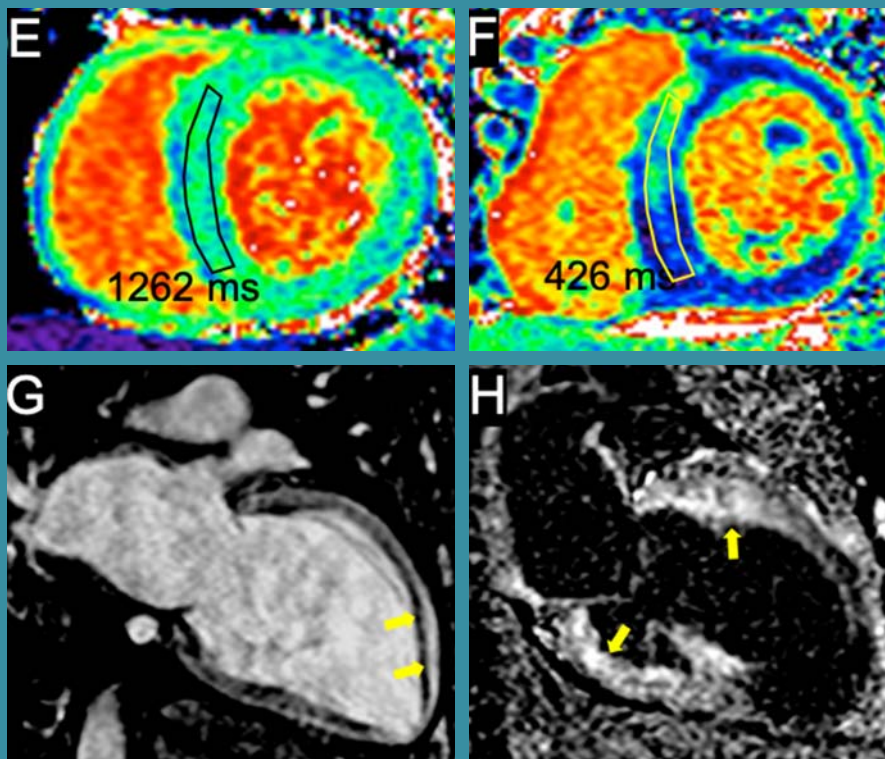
Non-contrast cine images (balanced steady-state free precession) in 4 chambers (A) and short axis (B) views respectively allow for morphological and functional assessment. The left ventricle (LV) was dilated and the interventricular septum was severely and asymmetrically hypertrophied. The LV ejection fraction was 35%. The right ventricular (RV) free wall was not thickened, however RV was severely dysfunctional, with an ejection fraction of 25%. The atria were only mildly dilated. Imaging of myocardial oedema in short axis view using the conventional T2-weighted sequences (C) and the more recently developed T2 mapping technique (D).
